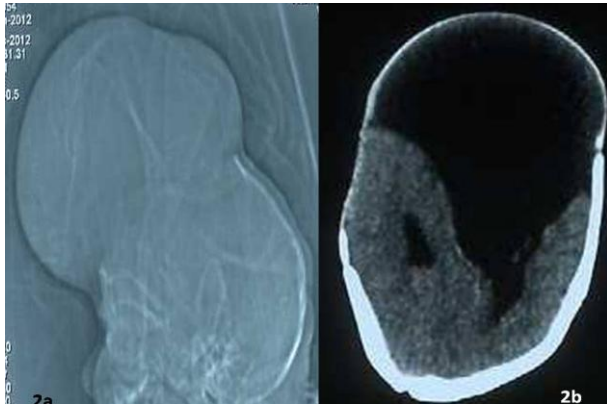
2a - Computed tomography showing defect in bony calvaria in sagittal section. 2b - Encephalocele communicating with lateral ventricle
